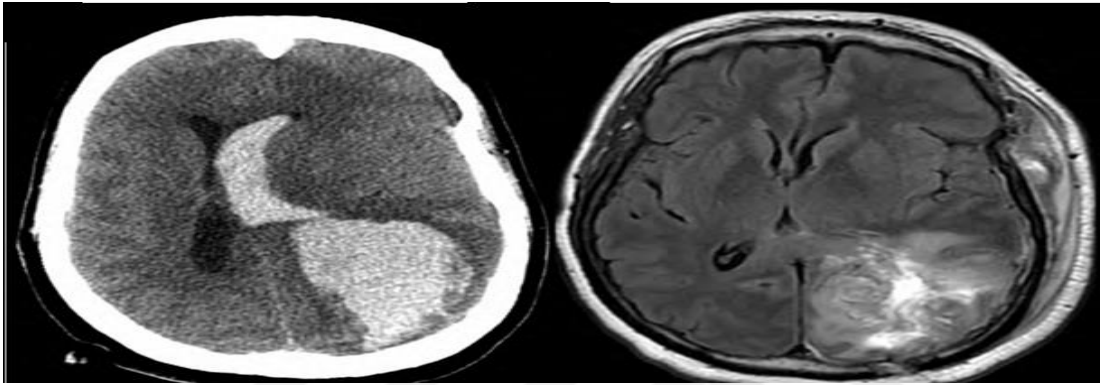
(Left) CT reveals head trauma with a large, hyper-dense, acute left parietal hematoma with surrounding edema. (Right) MRI of 11 days later reveals decreased edema region with residual T2 hyperintense blood products.
